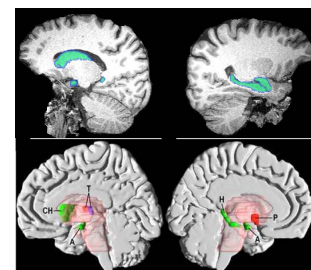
Brain regions with significant differences measured by standard resolution ASL MRI (upper) and SPECT (lower) in previous study (4).
